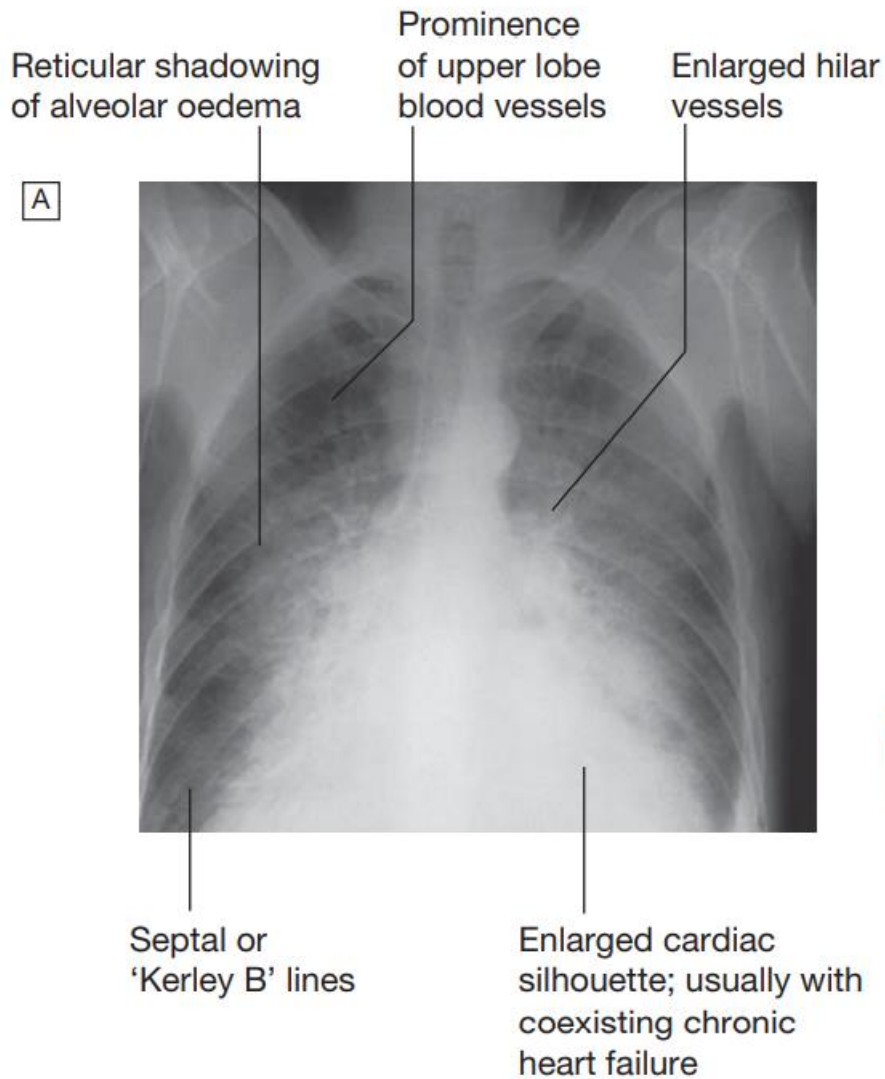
Radiological features of heart failure. A Chest X-ray of a patient with pulmonary oedema. B Enlargement of lung base showing septal or 'Kerley B' lines (arrow).
